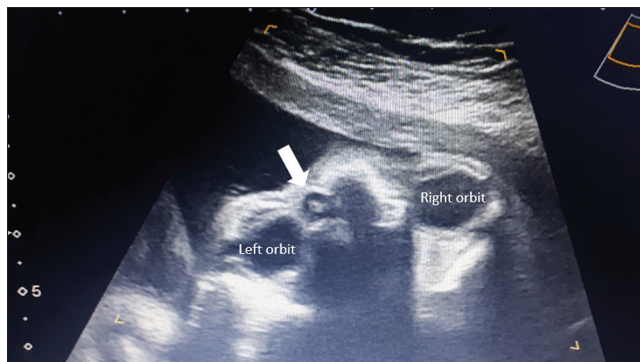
Ultrasound image of the orbital transverse plan. A hypoechogenic and circular image at the anterior and medial left orbital surface is pointed by a white arrow
